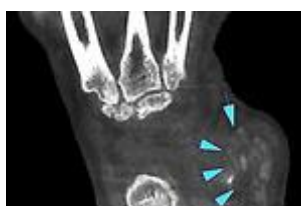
CBCT-image of the wright wrist with the presence of the podagric tofus (blue...
